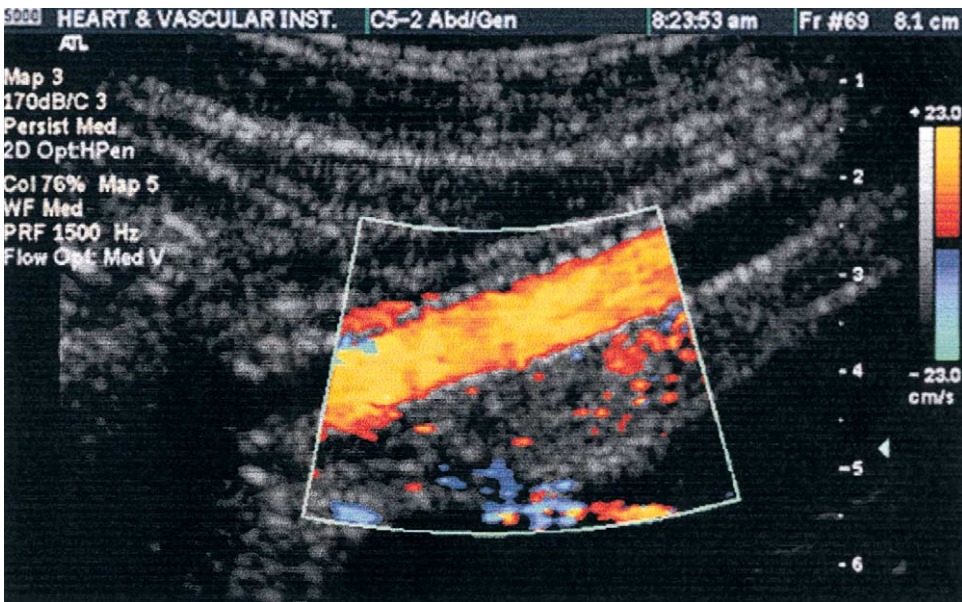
Arterial duplex ultrasound examination performed after placement of an endoluminal stent in the left external iliac artery. Note the smooth color flow within the stent. The struts of the stent are easily visible.
